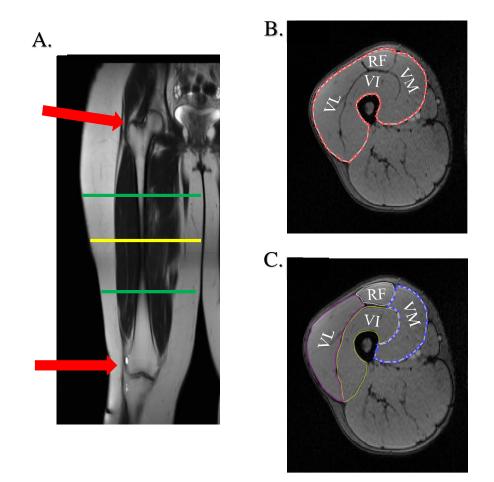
MRI acquisition area and 1-ROI vs. 4-ROI analyses. Panel A. Represents the coronal image of the right upper leg of a participant. The red arrows indicate the anatomical landmarks for the length of the femur; the greater trochanter (upper) and the lateral epicondyle (lower). The yellow line represents the location of a mid-femur slice, while the green lines represent the region in which all four quadriceps muscles are visible from axial images (4-to-4 region). Panel B. Represents an axial image of a participant with 1-ROI (red). Panel C. Represents an axial image of the same participant with 4-ROI (magenta= vastus lateralis, white= rectus femoris, yellow= vastus intermedius, blue= vastus medialis).
